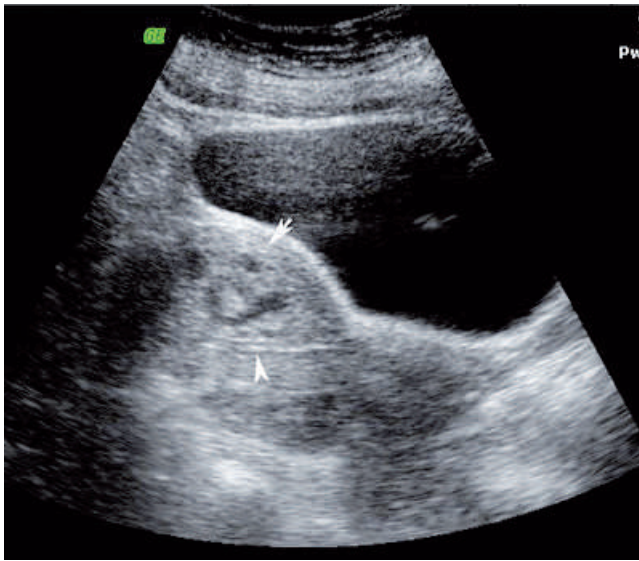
Gray-scale transabdominal longitudinal ultrasound image of a uterus showing multiple anechoic areas within the myometrium of the anterior wall (arrow) displacing the thin, linear endometrium (arrowhead).
